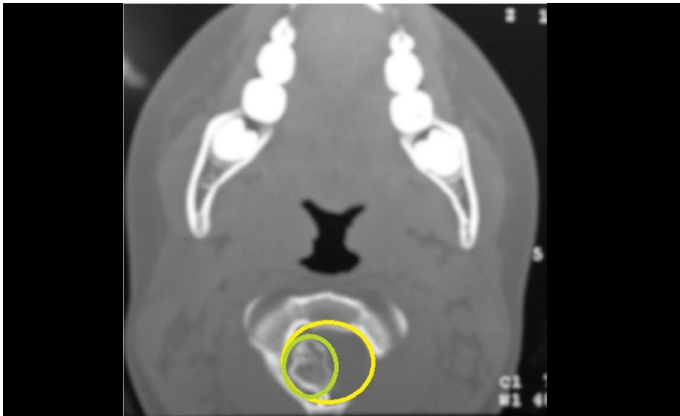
Axial CT scan of the same case as in the previous figure, showing the osteochondroma originating from the posterior arch of C1, and how to perform comparative measurements of the tumor and the canal.
